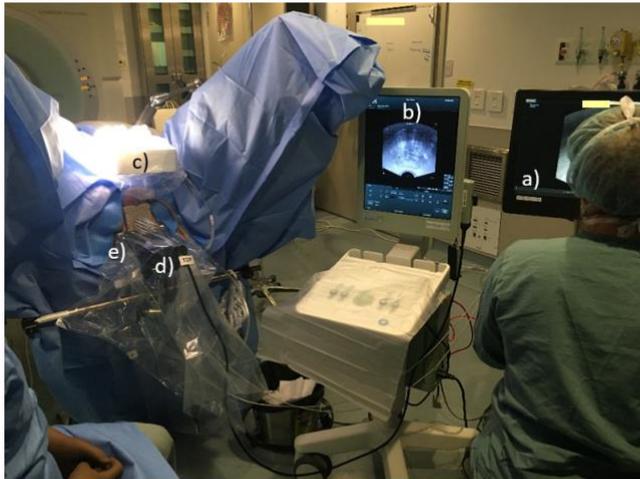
Clinical set-up for the Uronav Therapy System: a) planning station, b) BK ultrasound with 8848 probes, c) EM generator, d) stepper, e) EM captors
